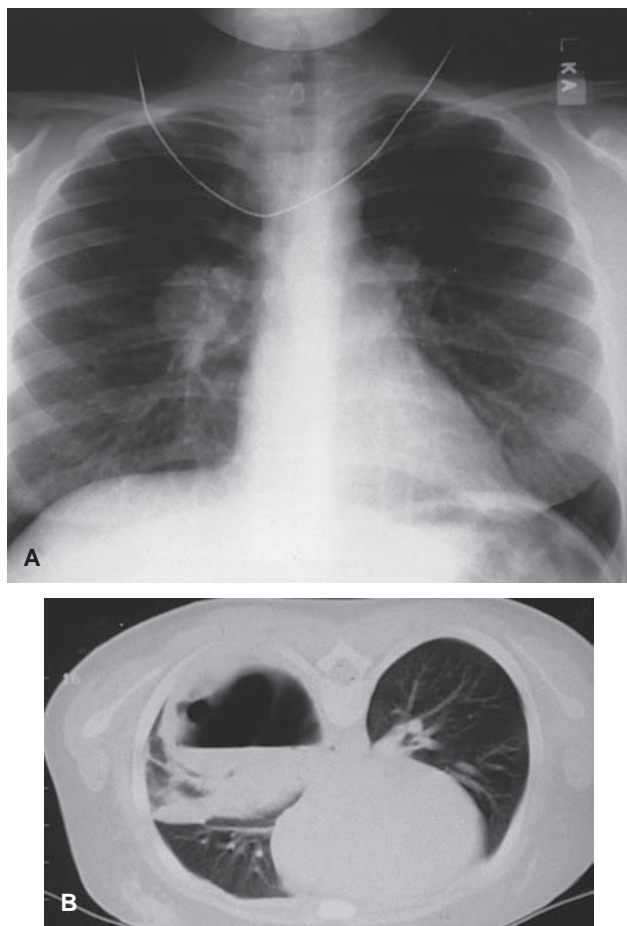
A: Plain film of a patient with a bronchogenic cyst arising from the right main stem bronchus. B: Computed tomographic scan of a similar lesion reveals large fluid-filled cyst compressing adjacent lung tissue.
